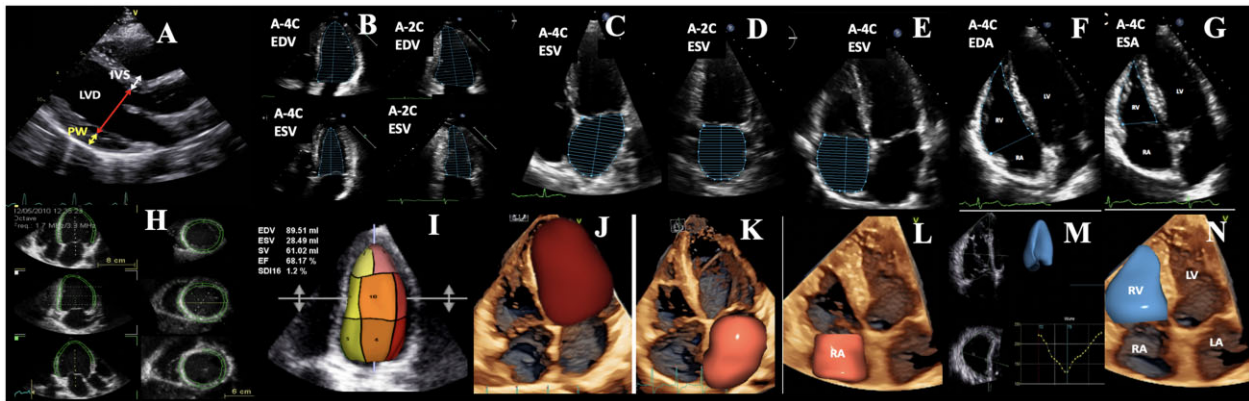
Assessment of cardiac chambers size and function by 2D and 3D echocardiography. (A) 2D measurement of LV diameters. (B–E) Estimation of cardiac volumes by summation method of disc (B: LV, C and D: LA, E: RA). (F and G) RV fractional area change assessment. (H–N) 3D echo assessment of cardiac chamber volumes (H–J: LV; K: LA; L: RA; M and N: RV).
